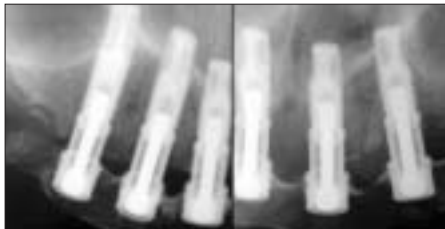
Postoperative periapical radiographs taken after implant surgery.
